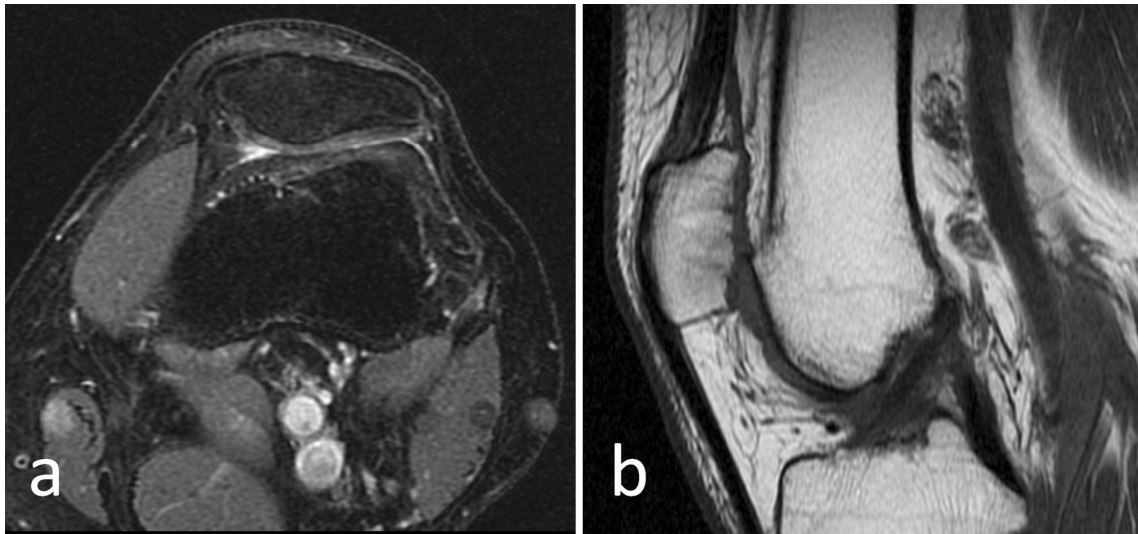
Final MRI examination, axial (a) and sagittal (b), of the patient shown in Fig. 1 at 24th month follow-up. Note the healing of the cartilage, consolidation and integration of the bone plugs
